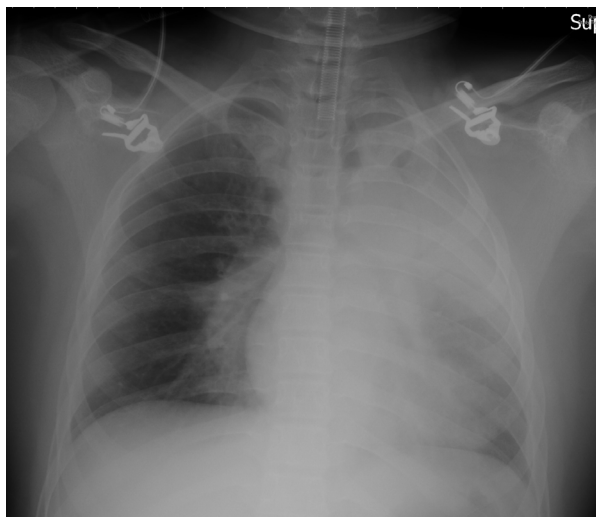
Chest radiograph revealed patchy consolidation in the left upper lobe.
